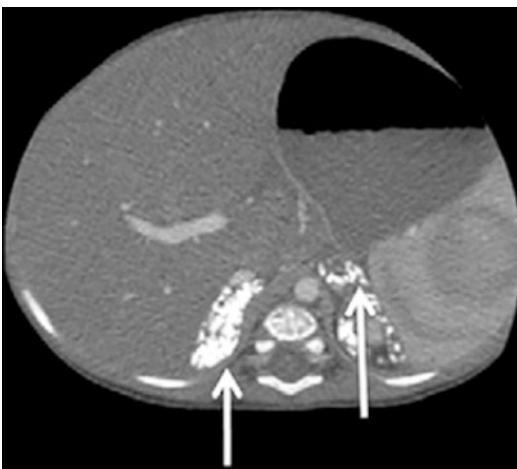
Liver ultrasonography showing signs of adrenal calcification (white arrows). (Figure and legend reproduced with permission from Valayannopoulos et al. [69])
